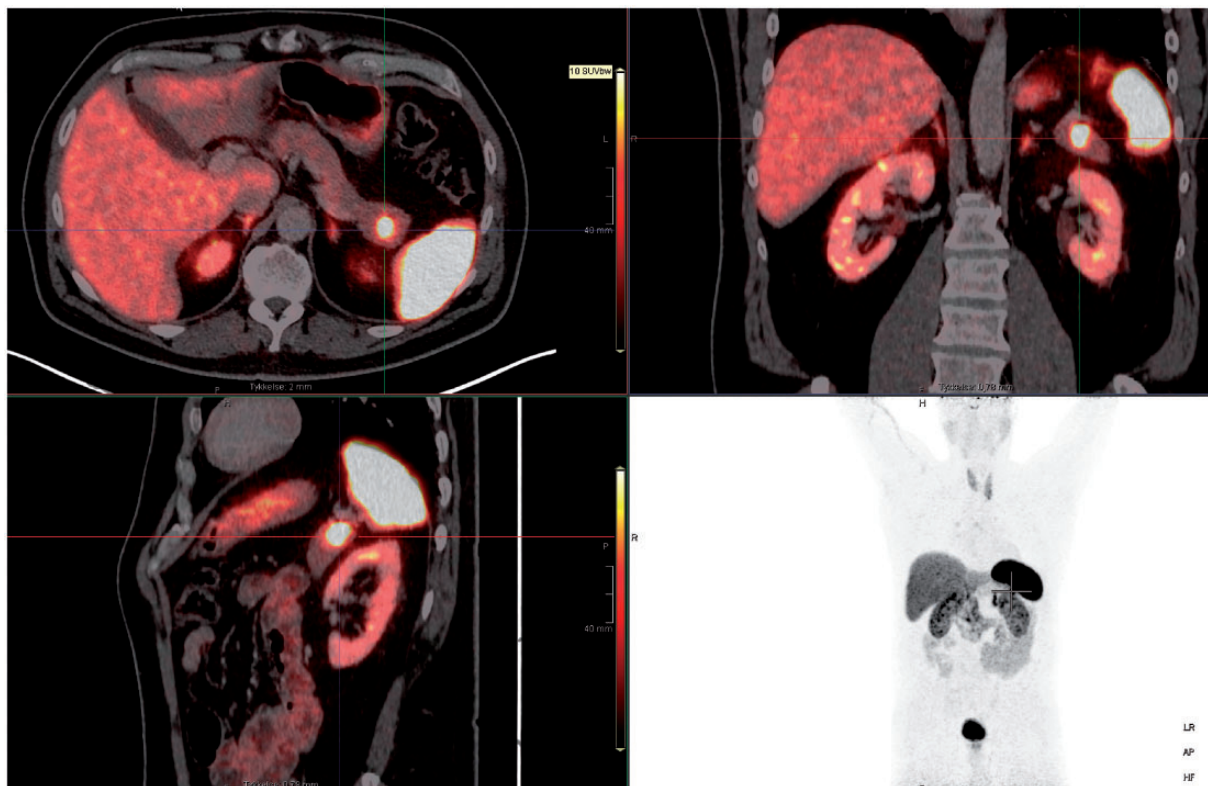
Case 1: Ga-68-Dotatoc PET/CT scan demonstrating a pathologic uptake in the tail of the pancreas with similar attenuation to the (physiologic) attenuation of the spleen.
